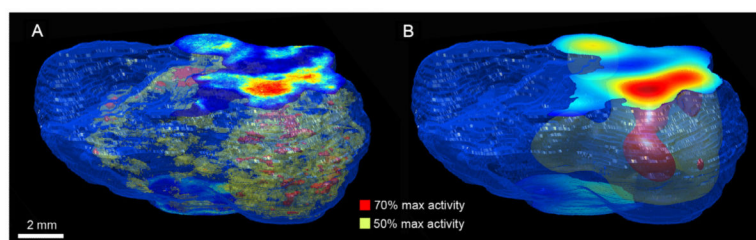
Rendered tissue outline with volumes segmented from the FDG images: (A) 3D reconstructed autoradiography; (B) sPET. Threshold values represent % of maximum intensity.
